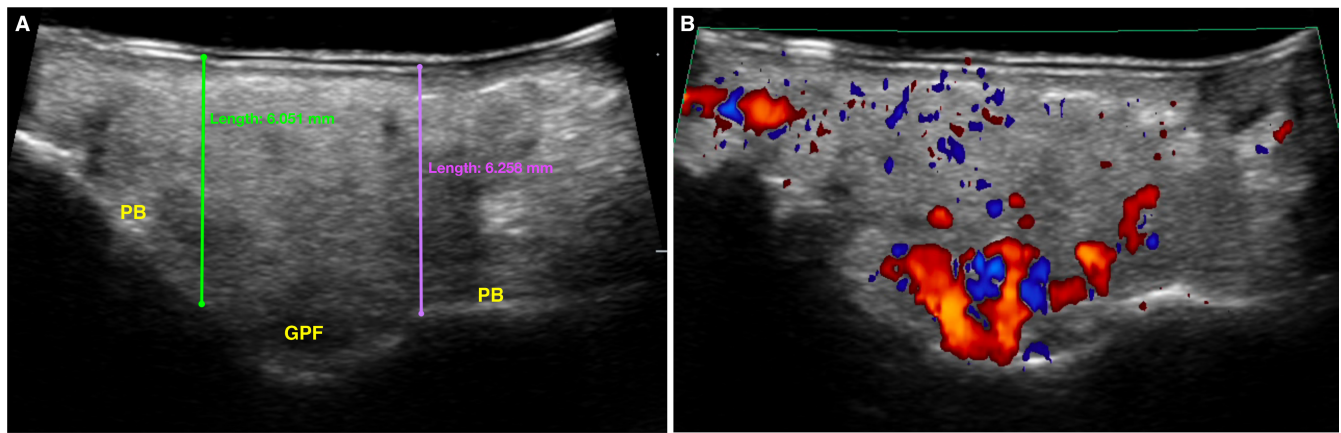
Nonionizing real-time ultrasonography for assessing the position of the greater palatine foramen (GPF). A, “B-mode” imaging showing the thickness of the palatal mucosa and the depth of the greater palatine foramen. The palatal mucosa presented as a hypoechoic (dark) region between two hyperechoic (bright) bands, which were the ultrasound probe (in the upper part of the scan) and the palatal bone (PB) (in the lower part of the scan). Measurements of palatal mucosa thickness were performed using a commercially available software package (Horos, version 3.3.6, Horos Project) as previously described by Chan and Kripfgans.²²⁵ B, “Color velocity” mode showing blood flow in the region examined. The displayed color velocity visualized the speed at which blood flows, and it was performed using a constant velocity scale (± 2.3 cm/s), with the color red indicating blood flow towards the transducer and the blue color denoting blood flow in the opposite direction. Note that blood volume was visualized and measured as videos generated from collected consecutive images; a still image is shown here. The location of the greater palatine foramen was identified by palatal bone morphology in the second molar region and by the increased blood flow in this area
